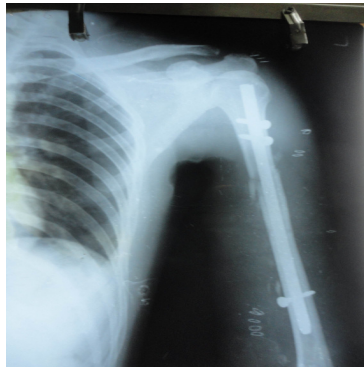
Post-operative X-Ray arm in slight internal rotation
